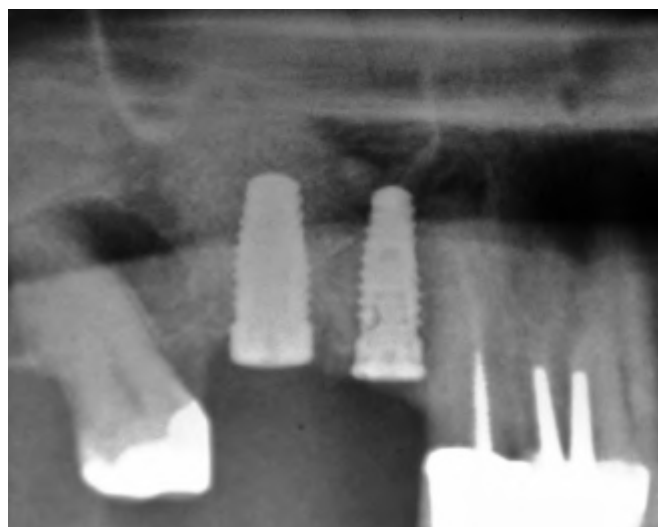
Radiograph of the same patient after implants were placed. The posterior implant was 5 mm in diameter; the anterior implant was 4 mm in diameter. The posterior implant replaced the first molar; the anterior implant replaced the second premolar.
